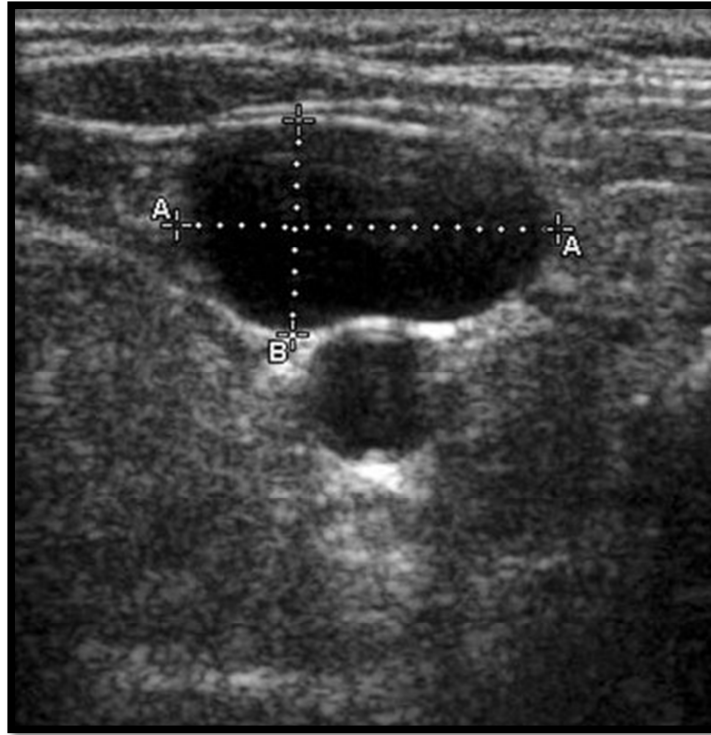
²⁸: Ultrasonographic image showing the relationship of IJV with CCA.
